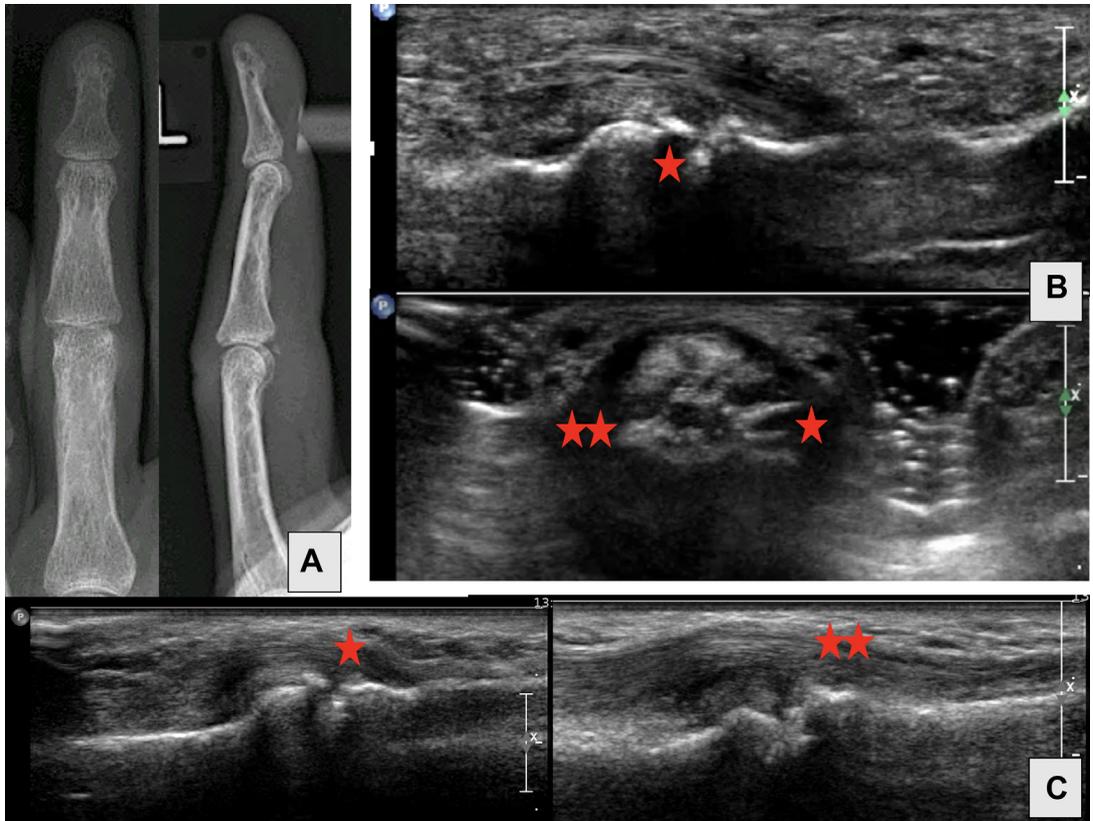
(A) Palmar plate avulsion, little fragment on radiograph. (B) Radial palmar plate fragment* with 1 mm dehiscence from base of middle phalanx, longitudinal, and additional small impression on ulnar side in axial view. (C) Radial* and ulnar stable fragments after 5 months.
